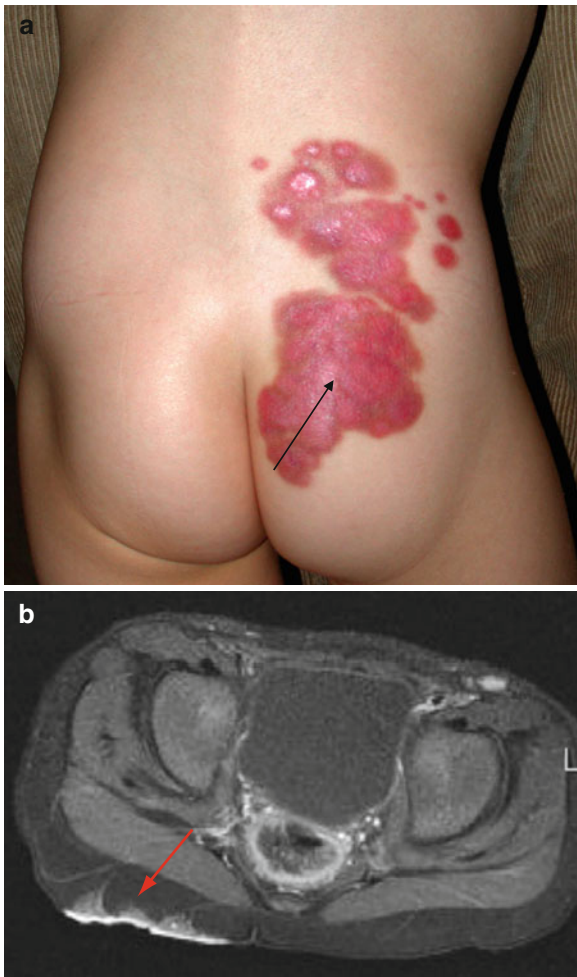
(a) Kaposiform hemangioendothelioma at the lumbosacral region. (b) Infiltrative growth in the subcutaneous region has been confirmed by MRI
